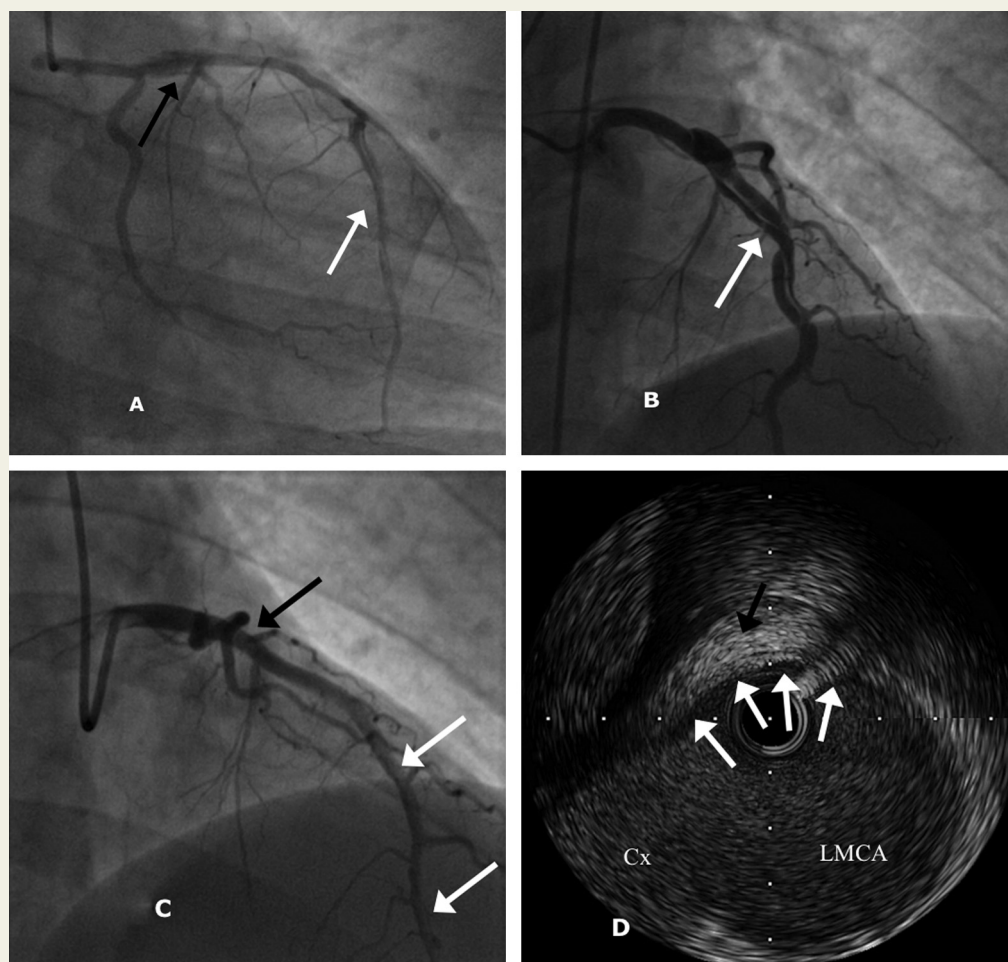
(A) - Case 1: Initial angiographic findings. Dissection is seen in the proximal LAD (black arrow) and involves the length of the vessel with a visible luminal flap in the mid and distal LAD (white arrow). (B) - Case 1: Follow up angiographic findings at five weeks. A luminal flap is seen in the proximal and mid LAD (white arrow). (C) - Case 1: Follow up angiographic findings at 29 weeks. Resolution of the proximal LAD angiographic abnormality (black arrow) with residual compromise of the true lumen in the mid and distal LAD (white arrows). (D) - Case 1: Intravascular ultrasound demonstrating resolving haematoma in the sub intimal space (false lumen) in the distal LMCA (black arrow). Cx = Circumflex coronary artery, LMCA = Left main coronary artery.
